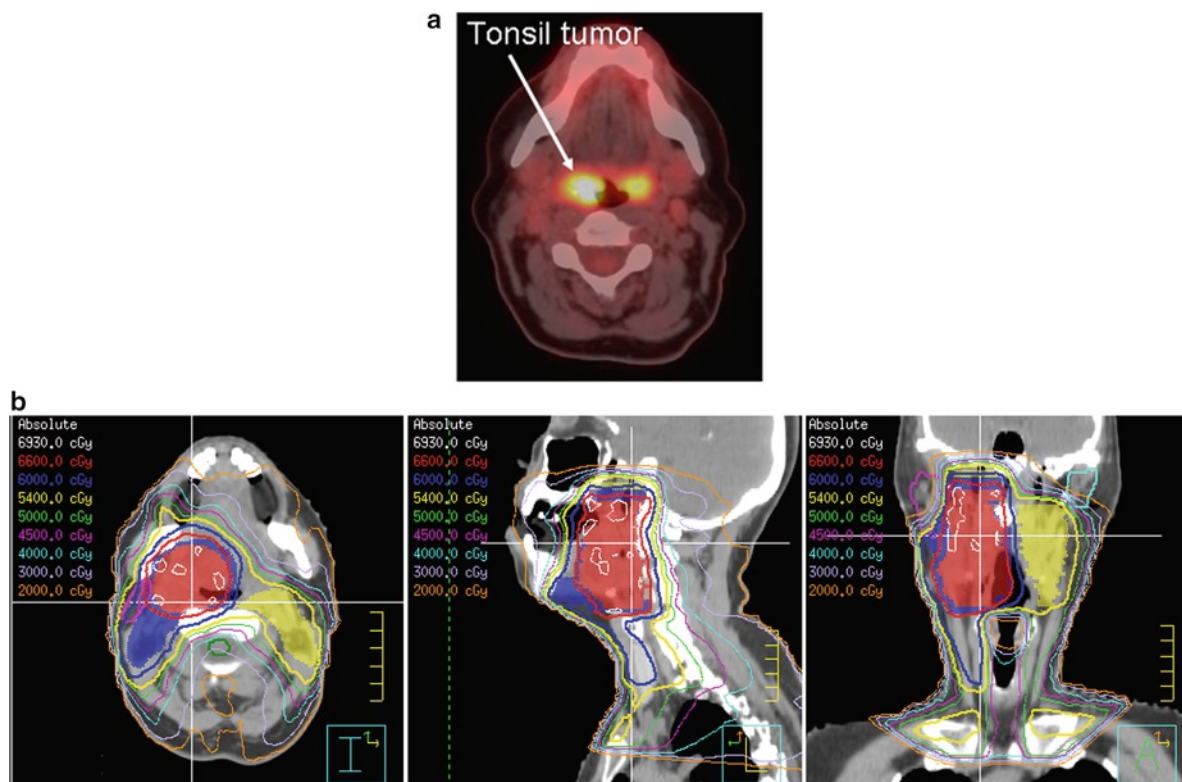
Tonsillar tumor (a) Initial PET/CT appearance of a T2 N2b right tonsil squamous cell carcinoma (b) IMRT treatment plan for definitive radiation of this lesion to a dose of 66 Gy in 30 fractions with concurrent cetuximab
